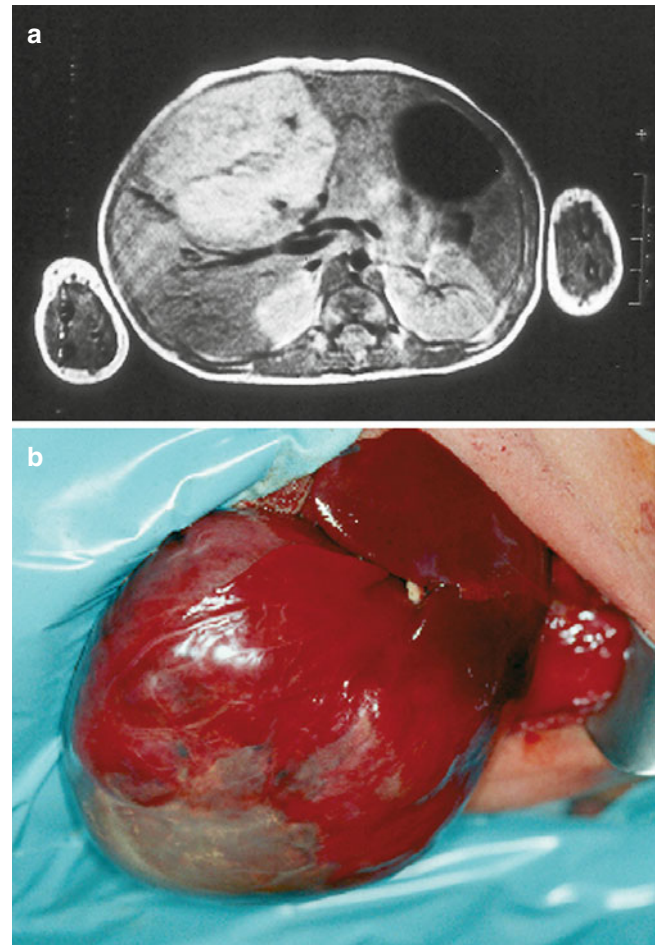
(a) MRI of the liver demonstrating a large intrahepatic hemangioma (b) Operative photograph showing a large hemangioma of the liver in a 1-month-old infant
